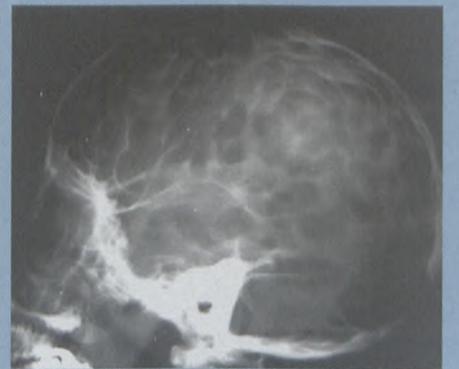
This six-year-old boy shows accentuation of convolutional markings of a silver/copper-beaten skull. The sagittal (not shown on this radiograph) and coronal sutures are completely fused, in keeping with craniosynostosis. The sellar demineralisation is in keeping with the resultant chronically raised ICP.
